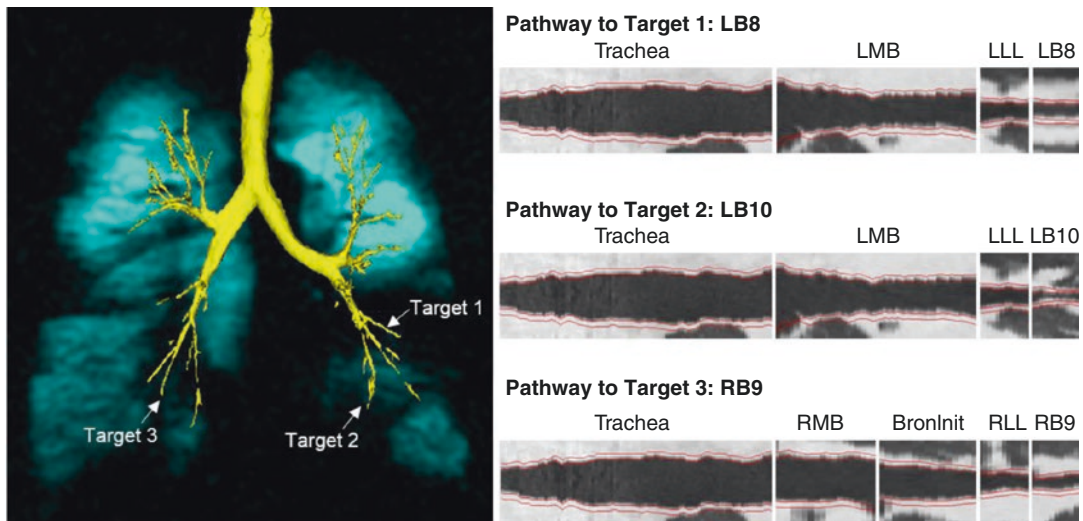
^3He ventilation defects and corresponding airways as targets for MRI-guided bronchial thermoplasty. ^3He static ventilation (blue) coregistered to the 3D-rendering of the airway tree (yellow) generated using CT. Three
